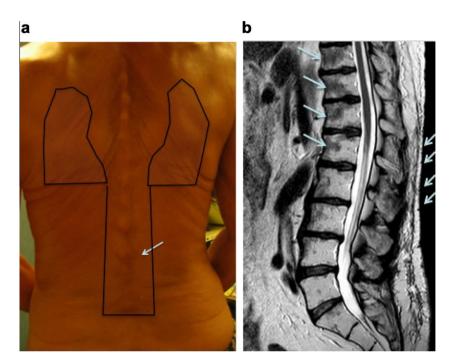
Lower limb radiation-induced radiculoplexopathy (RILP): (3a) clinical history: this 51-year-old man treated by 40 Gy total lymphoid irradiation for Hodgkin's disease, 26 years ago, has RILP corresponding to lumbar muscle-subcutaneous atrophy (RT field black full line); (3b) corresponding MRI in sagittal view with subcutaneous atrophy (arrow), pagetoid vertebra (arrow), without cancer recurrence.
